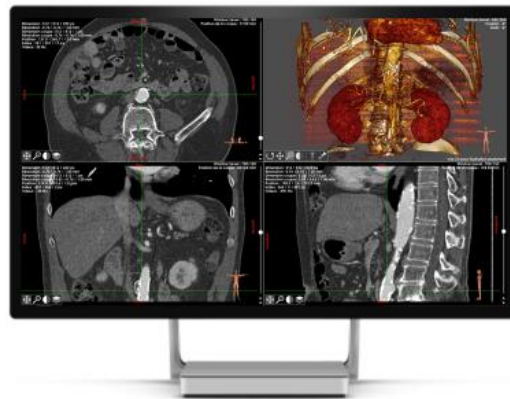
Preoperative CTA segmentation using Endosize®, sizing software, THERENVA. The segmentation process takes about 10 min.
